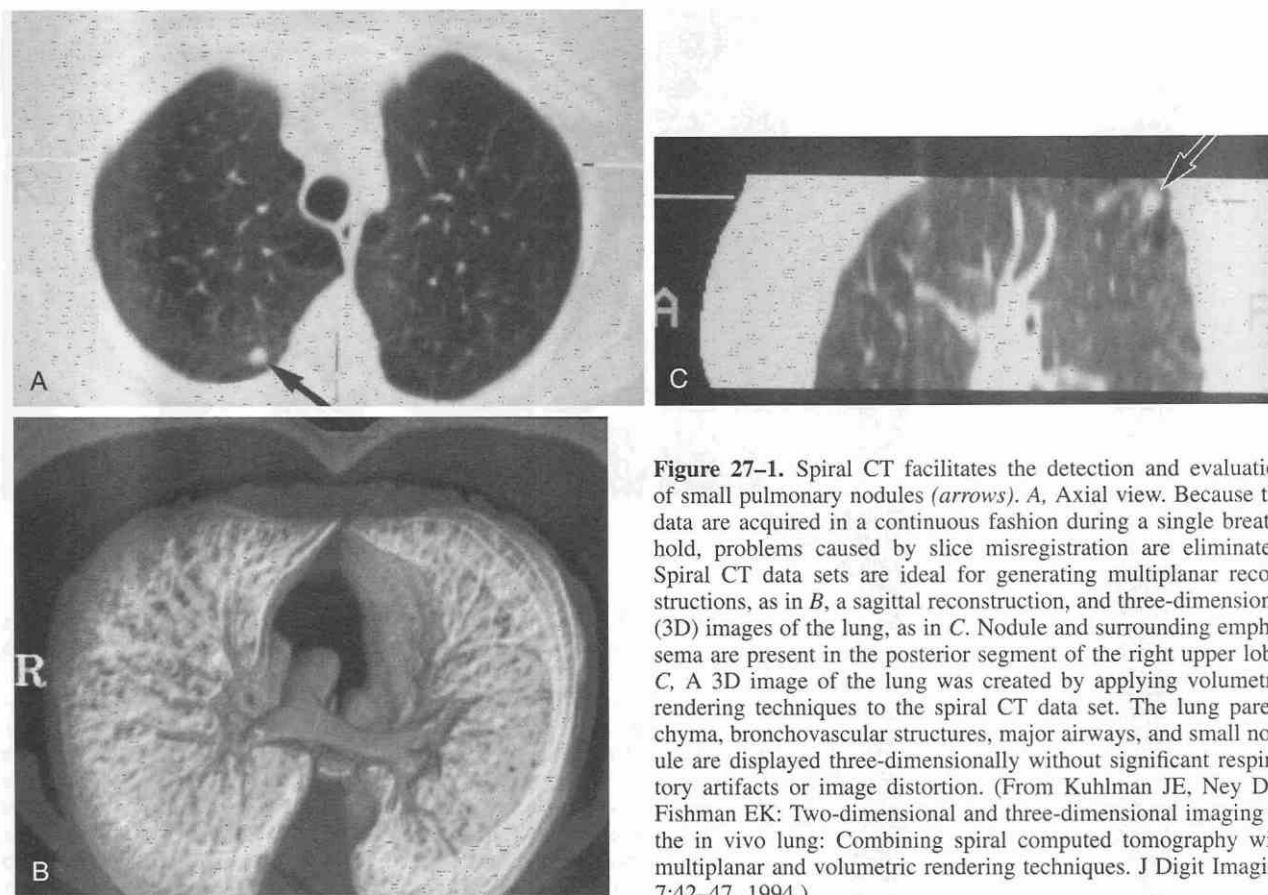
Spiral CT facilitates the detection and evaluation of small pulmonary nodules (arrows). A, Axial view. Because the data are acquired in a continuous fashion during a single breath-hold, problems caused by slice misregistration are eliminated. Spiral CT data sets are ideal for generating multiplanar reconstructions, as in B, a sagittal reconstruction, and three-dimensional (3D) images of the lung, as in C. Nodule and surrounding emphysema are present in the posterior segment of the right upper lobe. C, A 3D image of the lung was created by applying volumetric rendering techniques to the spiral CT data set. The lung parenchyma, bronchovascular structures, major airways, and small nodule are displayed three-dimensionally without significant respiratory artifacts or image distortion. (From Kuhlman JE, Ney DR, Fishman EK: Two-dimensional and three-dimensional imaging of the in vivo lung: Combining spiral computed tomography with multiplanar and volumetric rendering techniques. *J Digit Imaging* 7:42-47, 1994.)
